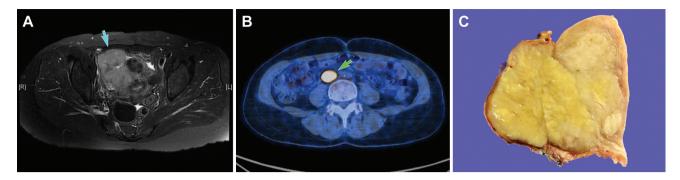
Imaging and gross findings. (A) Magnetic resonance imaging revealed a 7.1-cm-sized solid uterine mass (blue arrow). (B) Positron emission tomography-computed tomography revealed a hypermetabolic focus in the aortocaval area (green arrow). (C) Grossly, the uterine tumor was lobulated, with yellow-to-white, solid-cut surface, and involved the full-thickness myometrium.
